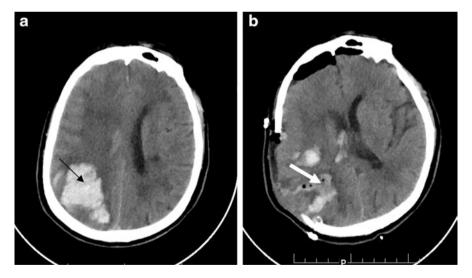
(a) CT scan of the brain showing a blood clot (arrow) in the right side of the brain. (b) CT scan of the brain of the same patient after a few days of decompressive surgery, showing the absence of bone flap and less amount of clot remaining (white arrow)
